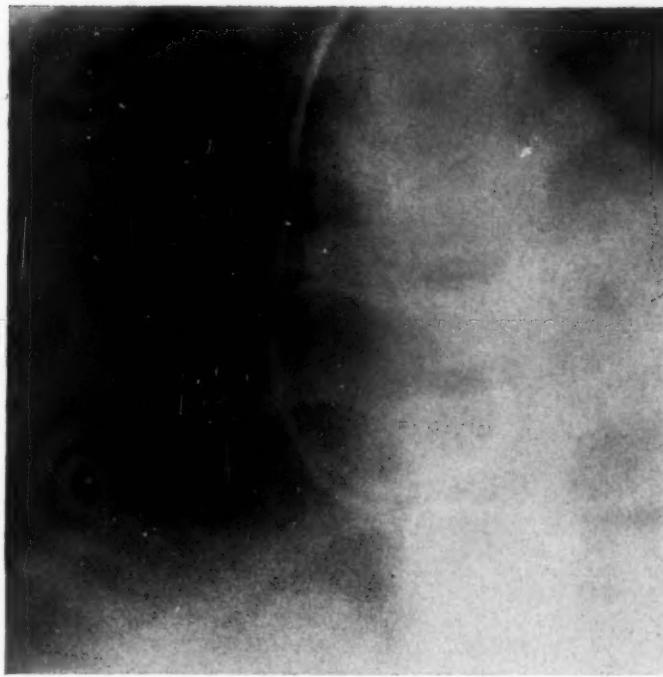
Case 10. Atrial septal defect. X-ray showing catheter tip in a right pulmonary vein, apparently entering this vein from the right atrium. (See Fig. 6.)
